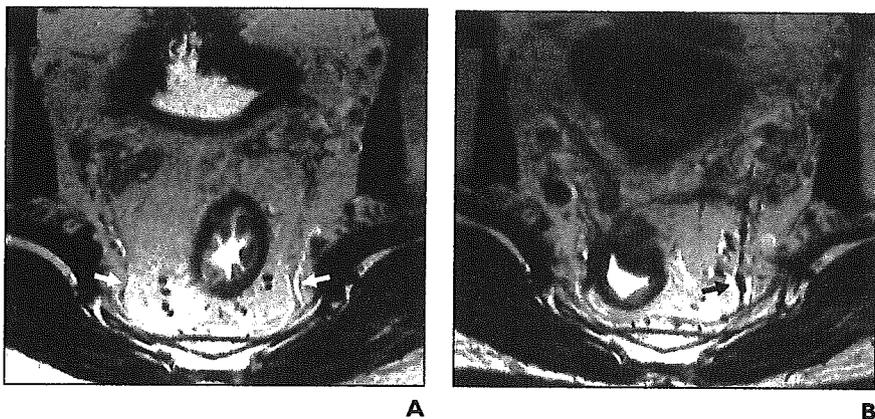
42-year-old man with rectal carcinoma. A and B, Comparison of pre- and postoperative MR images show pelvic plexuses are located just outside mesorectal fascia. MR image obtained before surgery (A) shows pelvic plexuses (white arrows). Postoperative MR image (B) shows one of metal hemostatic clips that were applied to inner surfaces of pelvic plexuses during surgery to mark their exact locations (black arrow).
